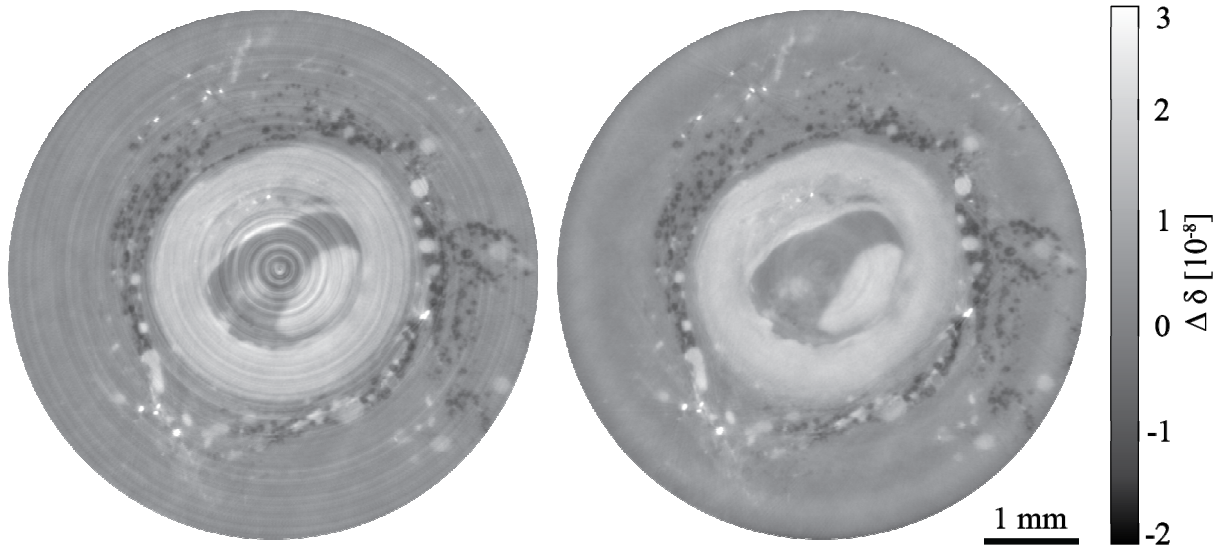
Human coronary artery slices from SR μ CT in phase contrast mode: unfiltered data (left) and data corrected using wavelet-Fourier filtering (right). A decrease in ring artifact effects is clearly visible (measurement performed at beamline P07, DESY, Hamburg, Germany).
